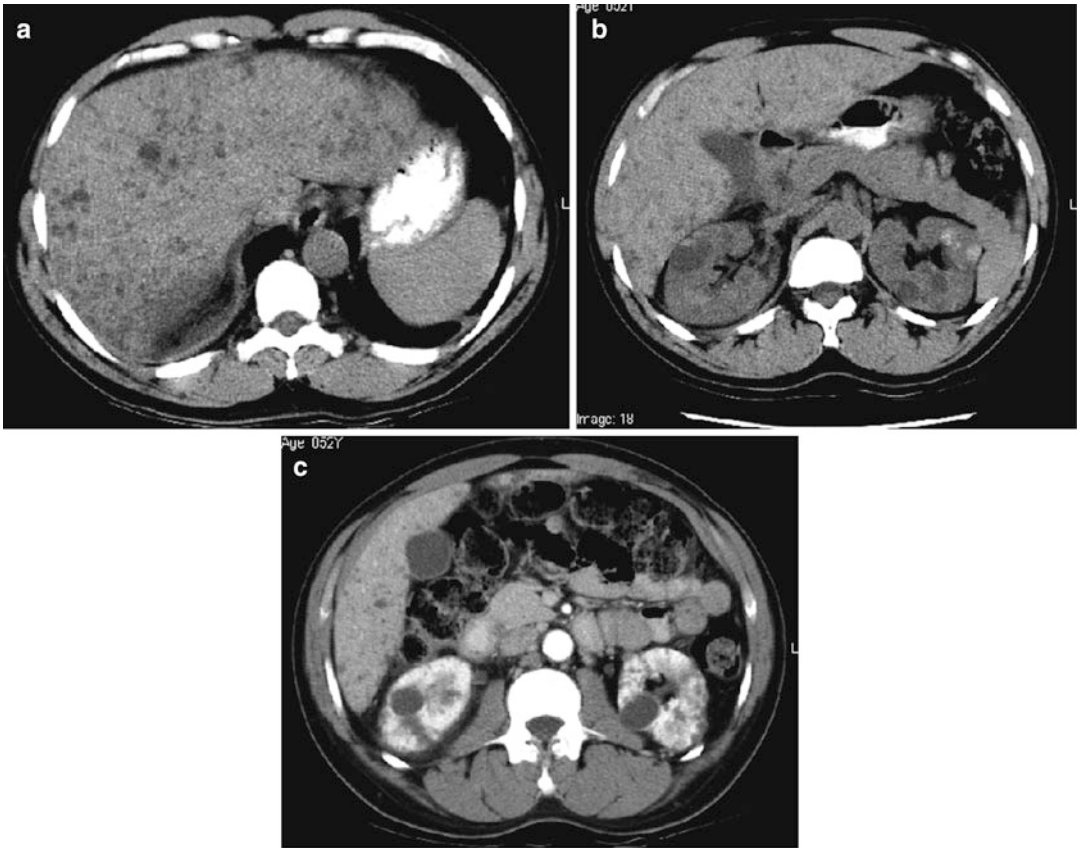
(a–c) Three CT scans of an adult patient with polycystic kidney disease with and without contrast showing multiple cysts in the kidneys and liver
